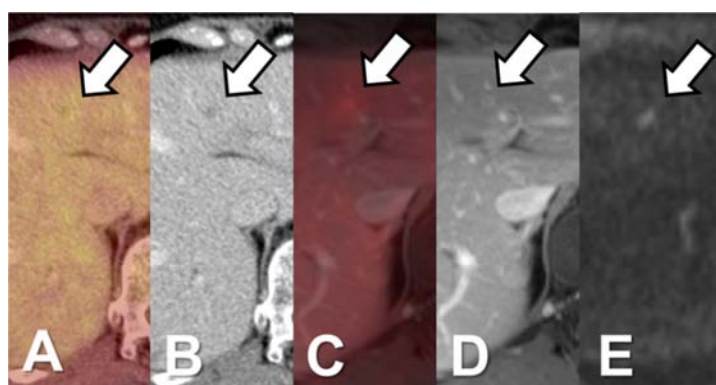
Patient with liver metastasis in segment IVa. PET/CT (A+B) shows small, hypodense liver lesion without elevated tracer uptake. In PET/MRI (C-E) the lesion shows a ring enhancement in T1 FLASH 2D (D) and diffusion restriction in DWI (E; B = 1000) as reliable signs of malignancy.
